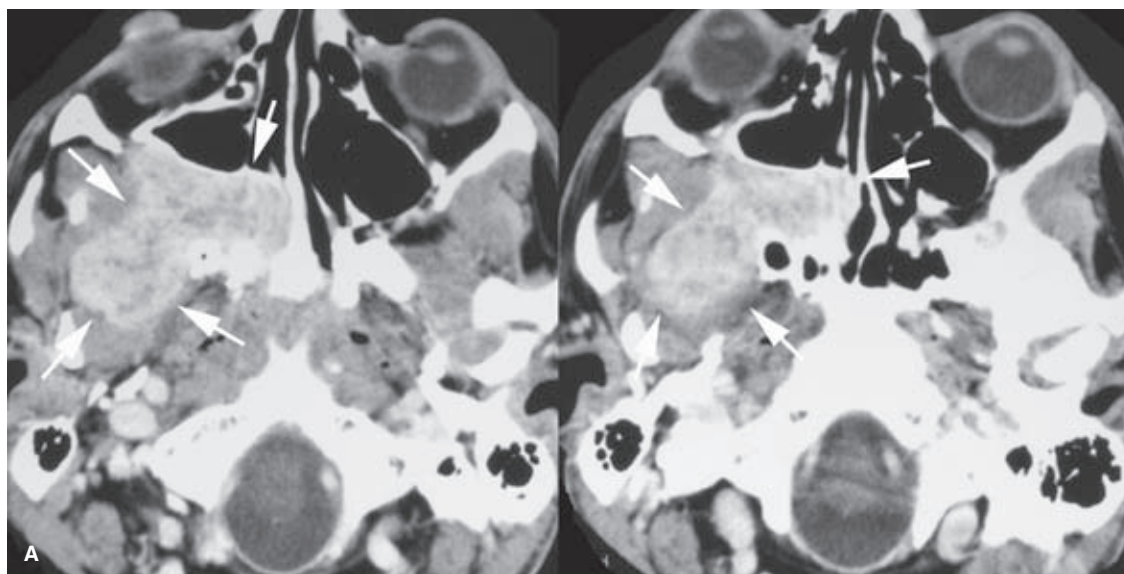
(A–E) Typical computed tomography (CT) and angiographic appearance of a JNA. A contrast-enhanced CT examination (A) demonstrates the hypervascular nature of this JNA in a teenaged male patient (arrows). There is expansion of the pterygomaxillary fissure and extension of tumor into the infratemporal fossa. Patients with this disorder typically present with nasal stuffiness or epistaxis. With more advanced tumor growth, expansion into the nasal passage will be expected and bone erosion of the skull base will allow intracranial invasion. (continued)
